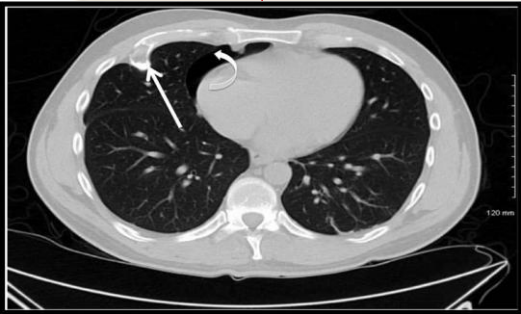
CT of chest without contrast showing lesion on posterior aspect of 4<sup>th</sup> rib (white arrow), and pneumothorax (curved white arrow). (Vemula, Shah & Willekes, 2012)
